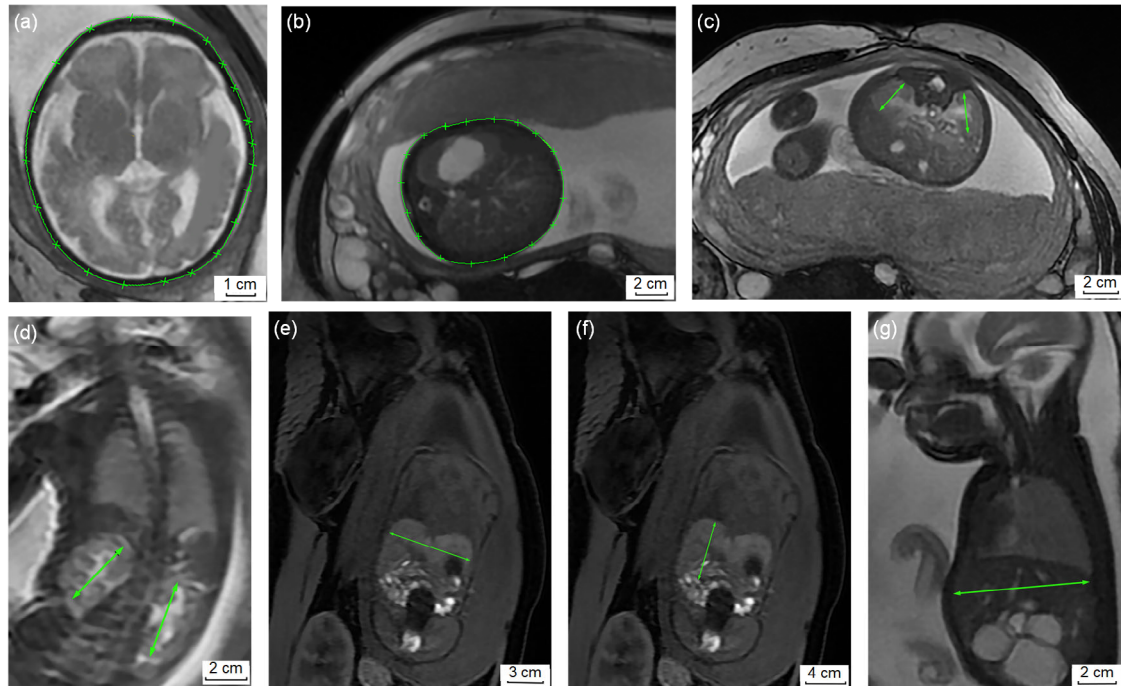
Magnetic resonance imaging (MRI) slices showing fetal measurements
